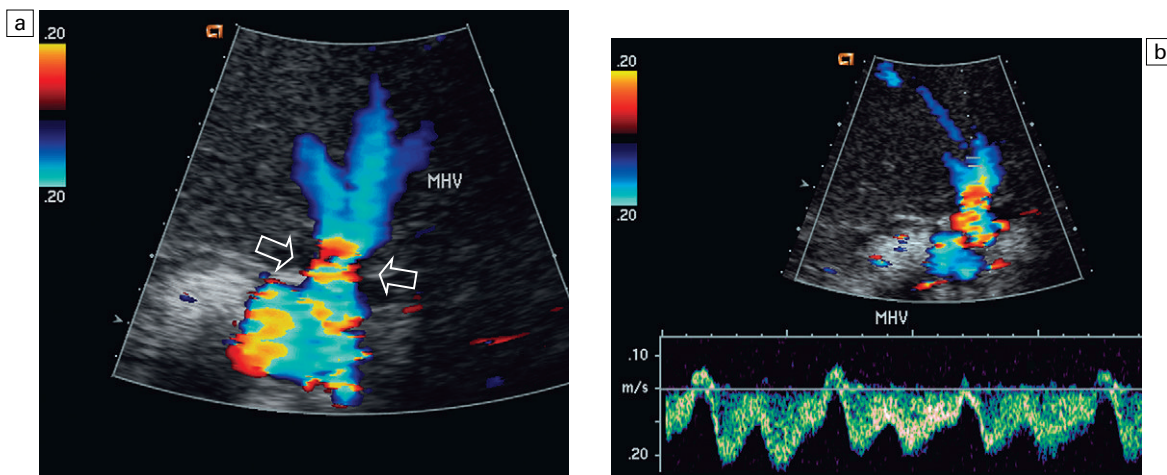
Transverse colour Doppler image of the hepatic vein/IVC anastomosis (a). Three hepatic veins are indeed patent. Aliasing however is perceived at the caval anastomosis (arrows). Spectral Doppler tracing (b) reveals normal cardiac periodicity transmitting into the liver. Since this waveform must propagate against the direction of flow, its presence within the liver effectively rules out significant hepatic venous outflow obstruction.
